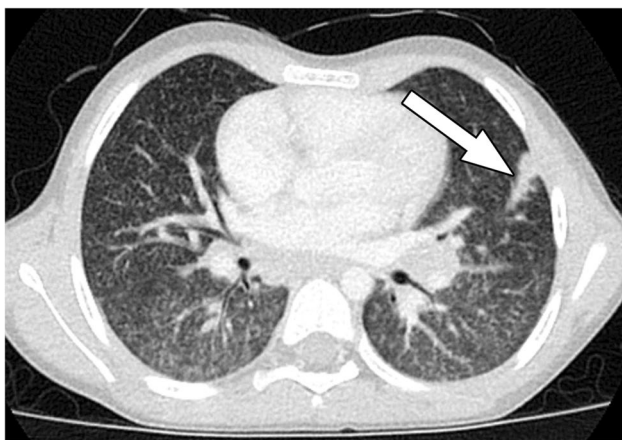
6-year-old girl with history of juvenile idiopathic arthritis and confirmed histoplasmosis. Axial chest CT image with IV contrast material shows a dominant nodule in the lingula with adjacent bronchovascular nodularity/beading (arrow) suggesting the primary site of infection as well as tiny nodules elsewhere in a miliary pattern suggesting disseminated infection
